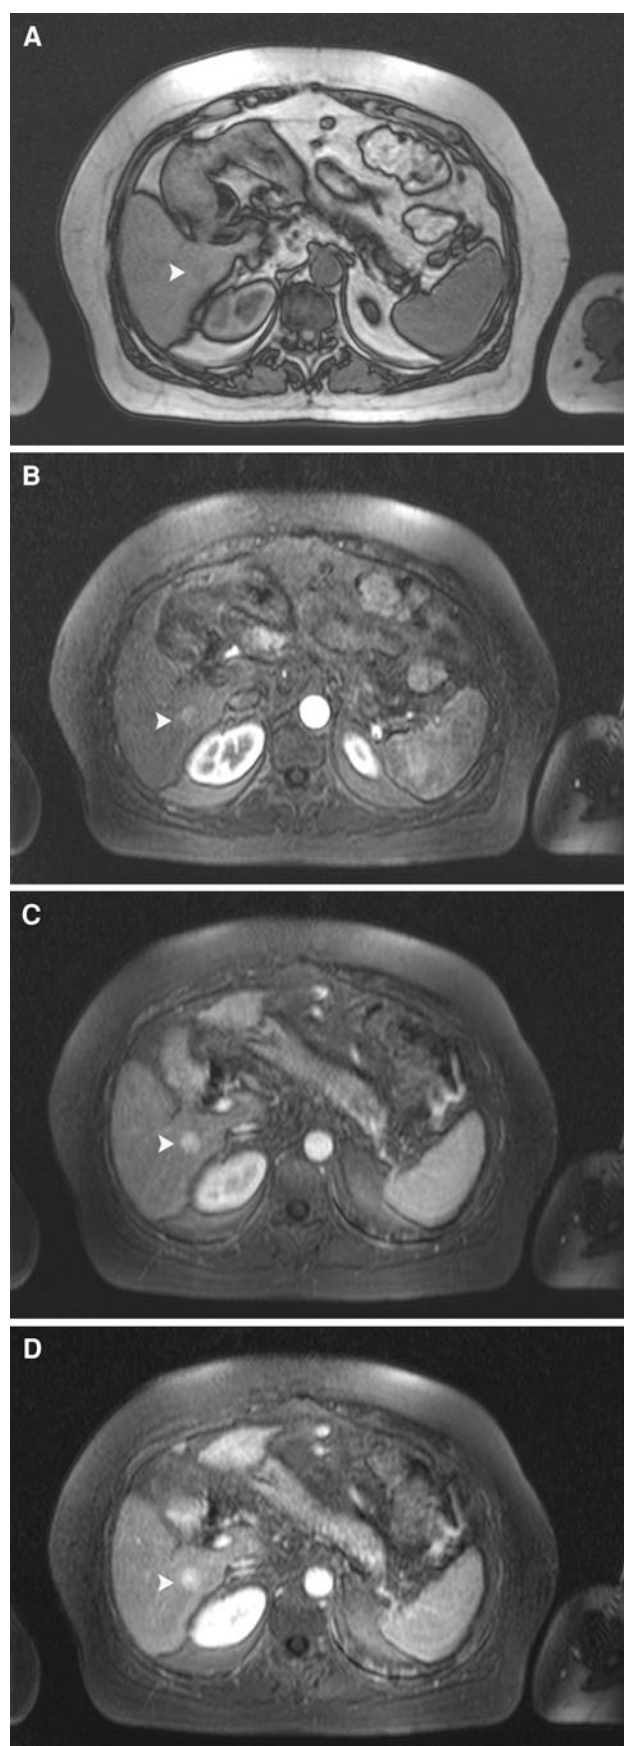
Intrahepatic cholangiocarcinoma in the IV hepatic segment in a patient with liver cirrhosis studied by MRI. A The arterial phase shows a nodule with a rim hyperenhancement. B At the portal phase progressive uptake of intravenous contrast media is seen until complete enhancement of the lesion.
